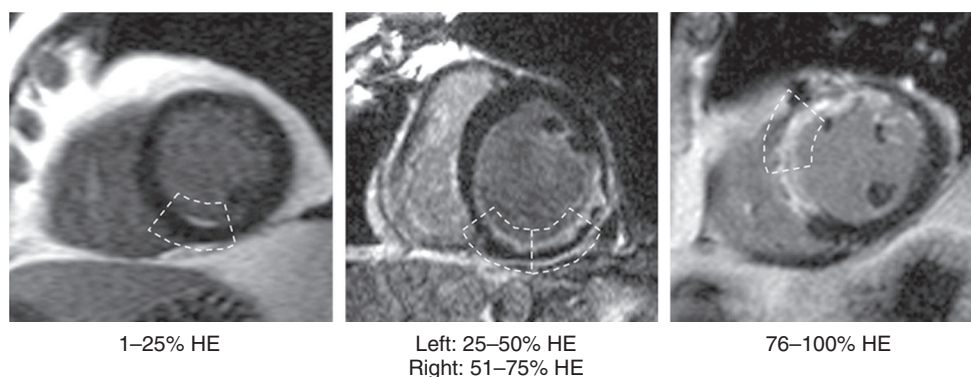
e10 Typical delayed-enhancement cardiac magnetic resonance images showing myocardial segments (*dashed white lines*) with various degrees of hyperenhancement. HE, Hyperenhancement. (From Kim RJ, Shah DJ, Judd RM: How we perform delayed enhancement imaging. *J Cardiovasc Magn Reson* 5:505–514, 2003.)
